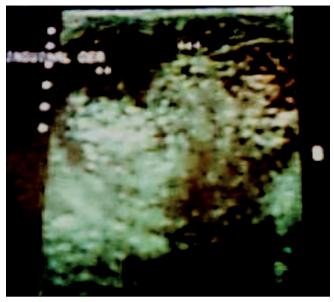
Gray-scale ultrasound. Cystic lesion is observed with heterogeneous content, which causes posterior reinforcement.
